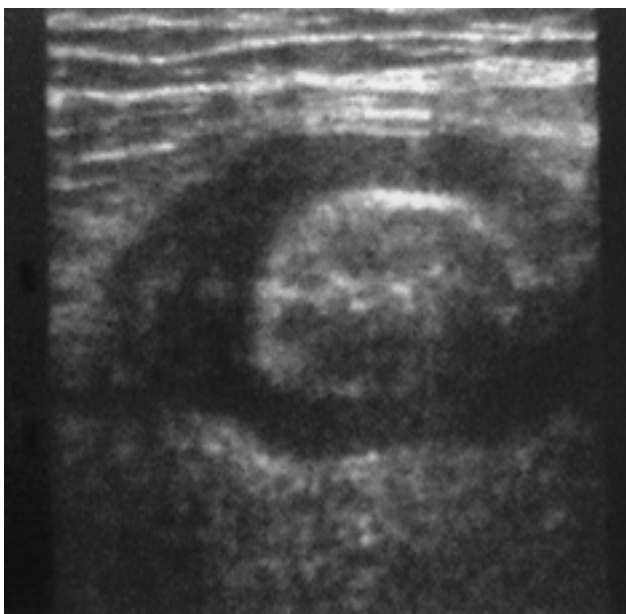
Ultrasonographic appearance of circular wall thickness at the sigmoid-descending colon junction
